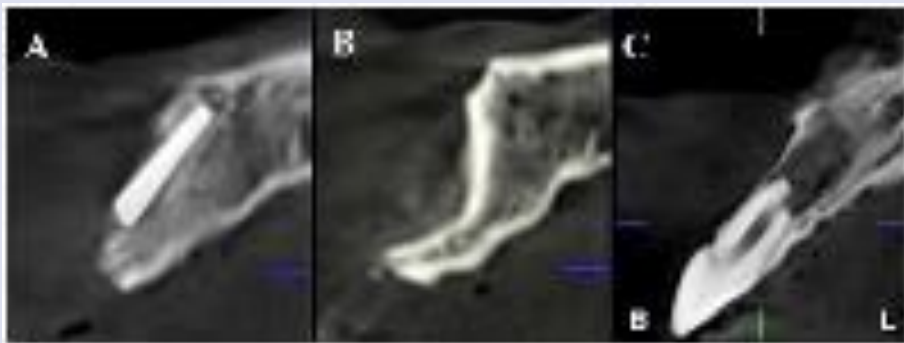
Cross sections in CBCT (A and B) showing buccally placed residual endodontic material with bony defect seen on the buccal aspect of 11 region. C) Root resorption resembling external apical inflammatory resorption seen in 11 with periapical pathology.
